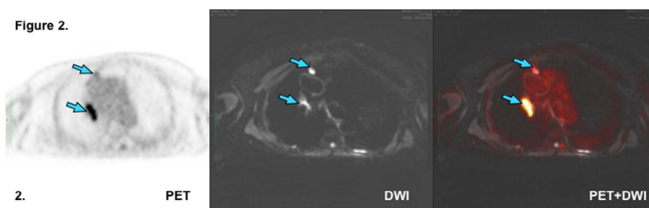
PET and DWI images with PET+DWI fusion images demonstrates mediastinal lymphadenopathy that both restricts diffusion and is FDG avid.
